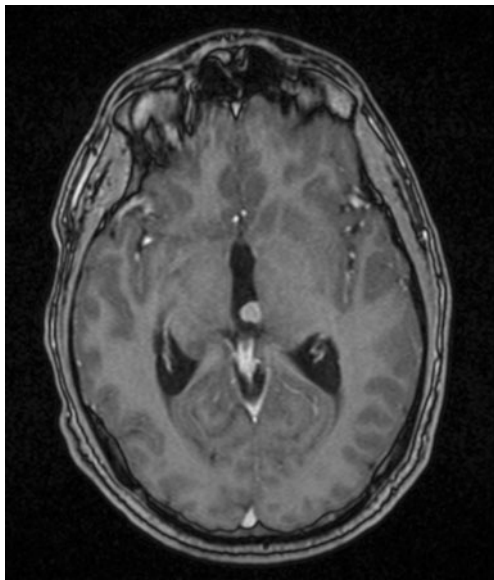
Axial T1-weighted MRI demonstrating a intraventricular lesion in the posterior aspect of the third ventricle
